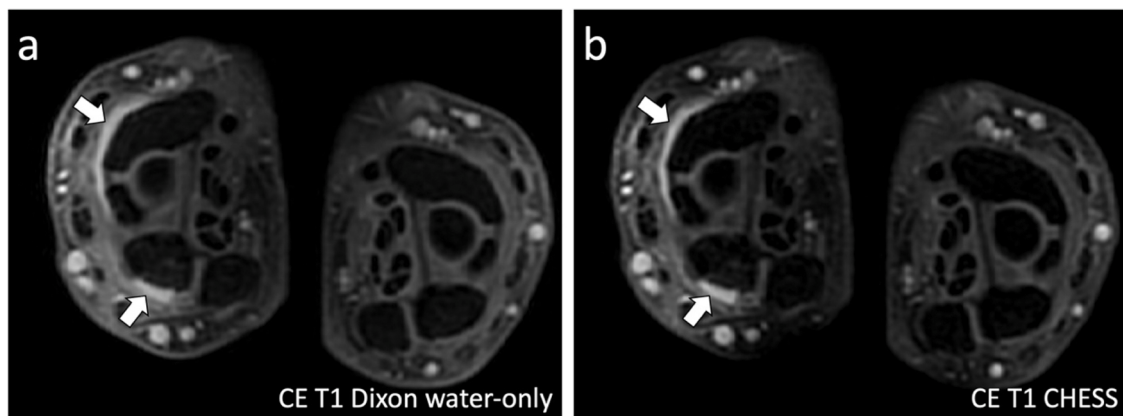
Similar appearance of radio-carpal joint synovitis (white arrows) on axial contrast-enhanced 3D GRE T1-weighted (a) Dixon water-only and (b) CHES images in a 30-year-old woman with early RA.
